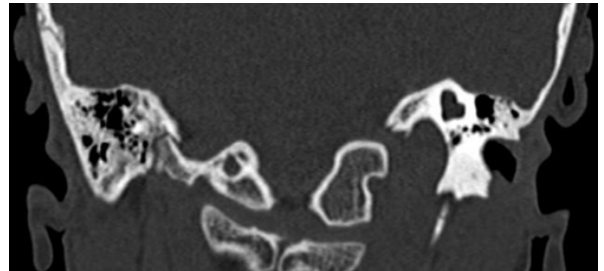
Coronal CT image showing left common cavity.
